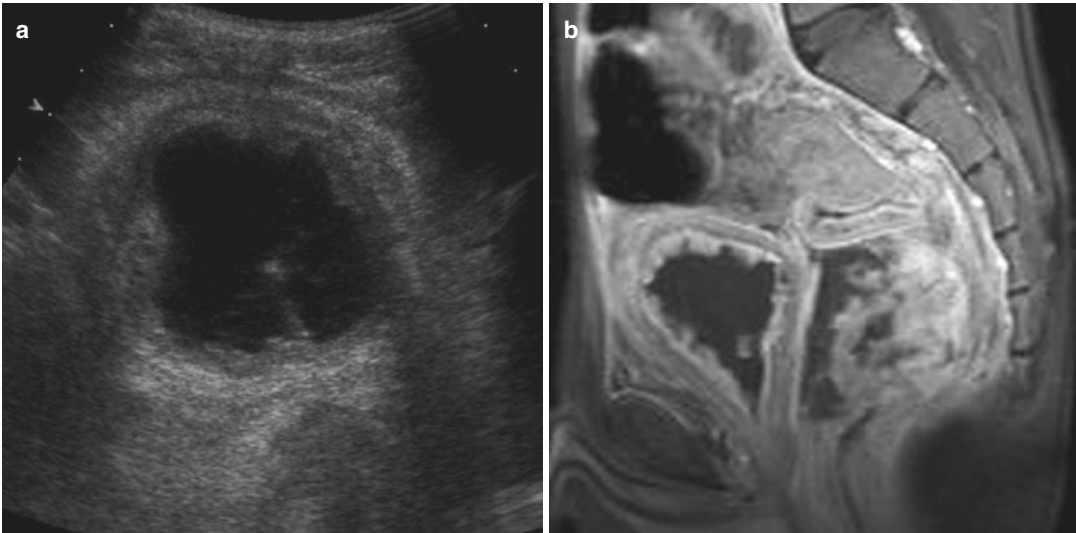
HSP in a 12-year-old-boy with involvement of the bladder. (a) US: sagittal scan; marked irregular thickening of the bladder wall. (b) MR imaging T1-weighted
